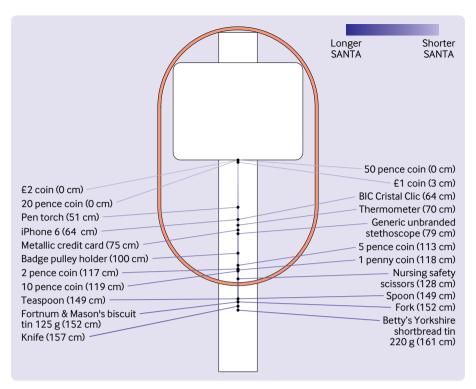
Measurement of site where applied newtonian mechanics triggers acceleration (SANTA). Magnified view of the MRI (magnetic resonance imaging) room layout, with SANTA values of the objects drawn to scale along the launch axis
